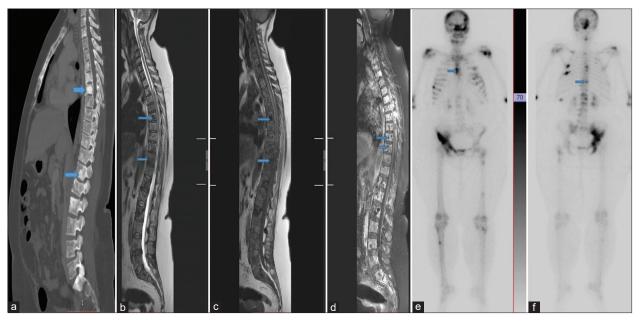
Radiological representative images of bone metastasis: Images of a 50-year-old female patient of breast cancer with extensive axial skeleton osseous metastasis. Magnetic resonance imaging whole spine (a) T2 weighted, (b) T1 weighted, (c) contrast-enhanced mid-sagittal slices, (d) computed tomography scan mid-sagittal slice, bone window settings, and (e and f) Bone scan, anterior and posterior planer images. Blue arrows are sites of axial skeleton osseous metastasis.
